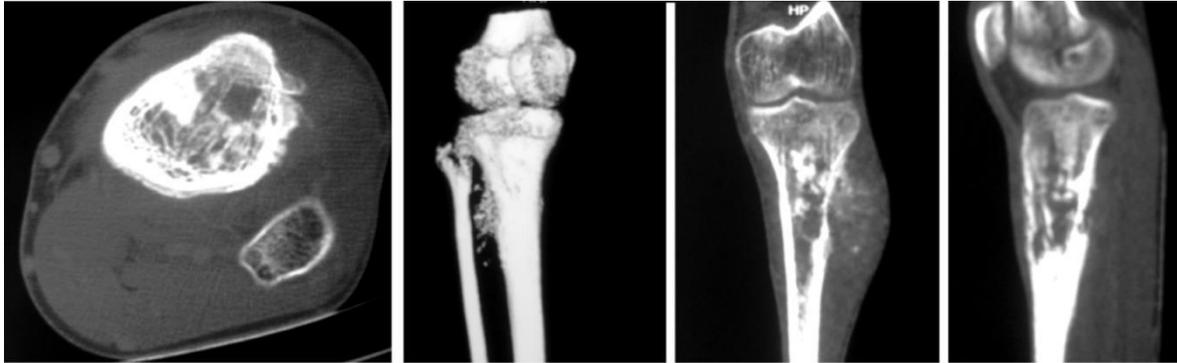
CT showing an expansive process of the proximal third of the left tibia with an approximately 70mm, with periosteal reaction and muscular invasion.
